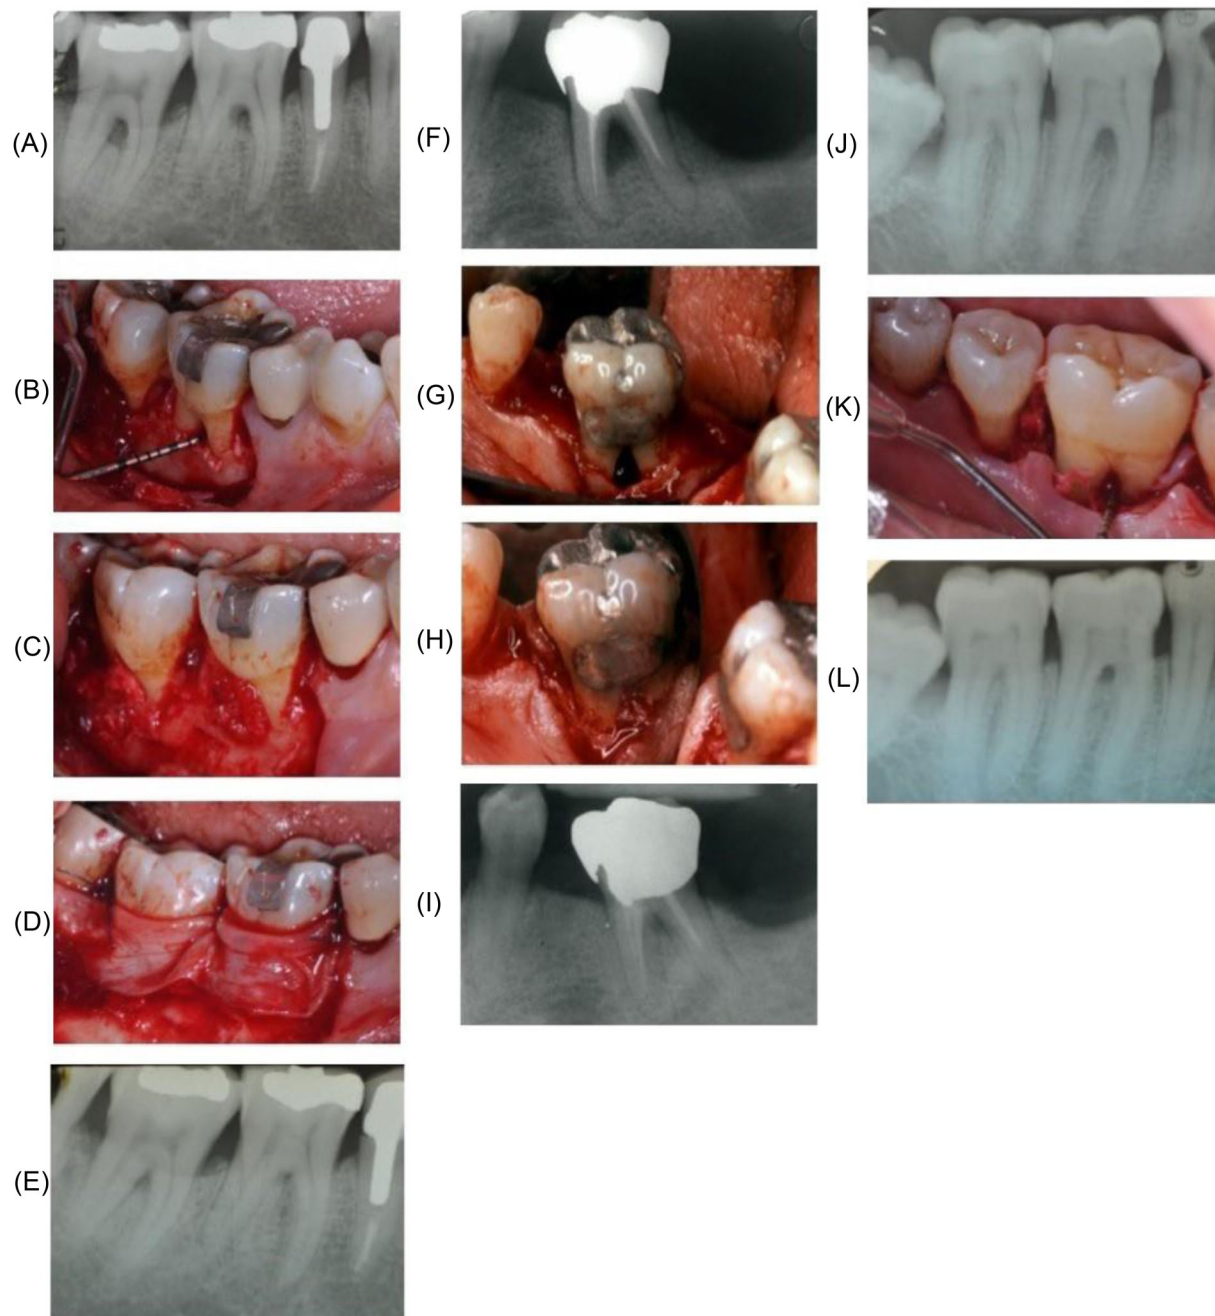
(A) Periapical radiography of the OFD+ABG+L-PRF site at baseline. (B) Buccal degree II furcation involvement after debridement. (C) The furcation defect is filled by autogenous bone graft. (D) The graft is covered by the L-PRF membrane. (E) Periapical radiography of the OFD+ABG+L-PRF site at 6 months after surgical treatment. (F) Periapical radiography of the OFD+ABG site at baseline. (G) Buccal degree II furcation defect after debridement. (H) The furcation defect is filled by autogenous bone graft. (I) Periapical radiography of the OFD+ABG site at 6 months after surgical treatment. (J) Periapical radiography of the OFD site at baseline. (K) Lingual degree II furcation defect after debridement. (L) Periapical radiography of the OFD site at 6 months after surgical treatment
